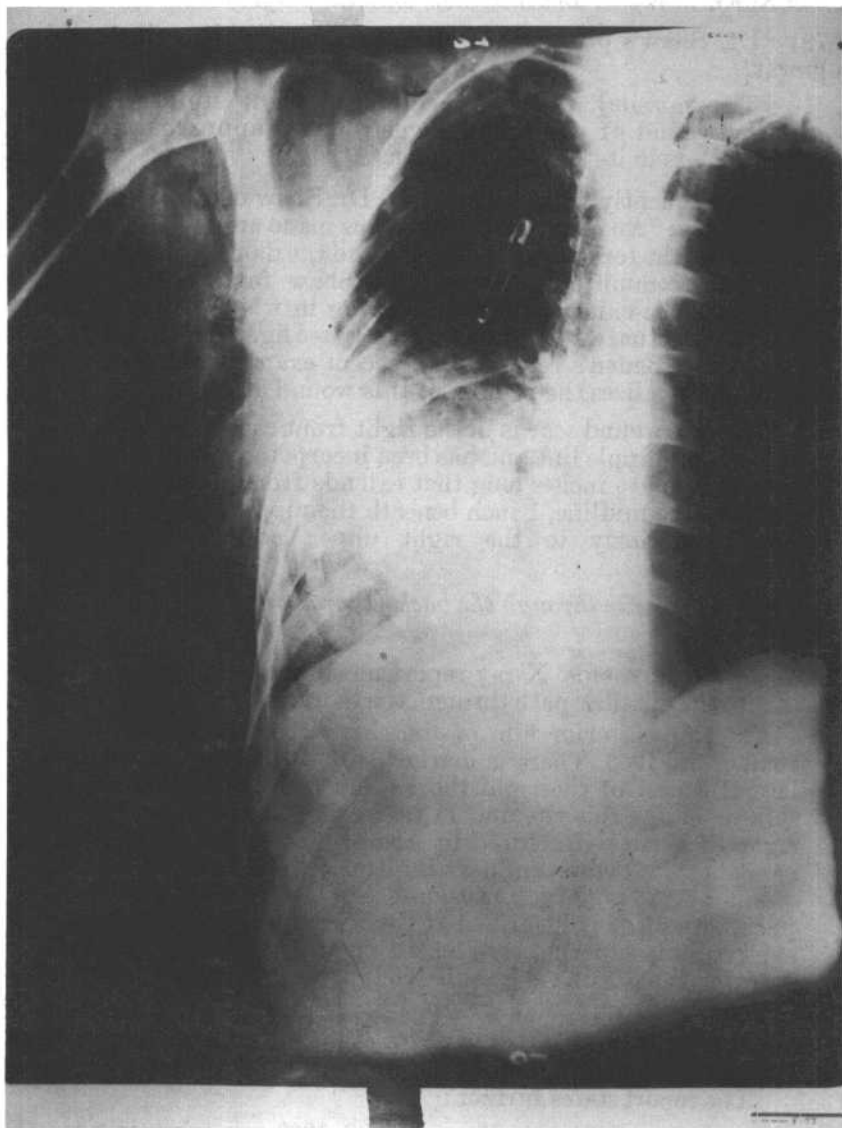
Photograph of the anterior-posterior X-Ray film of the chest of Governor Connally, showing the multiple fractures of the right fifth rib and the contusion of the right lung.
